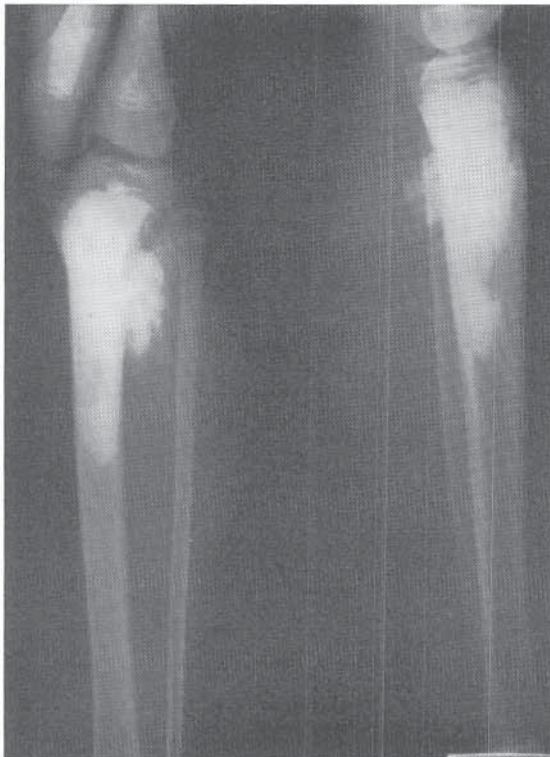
Osteogenic sarcoma of the proximal tibia: initial radiograph.
